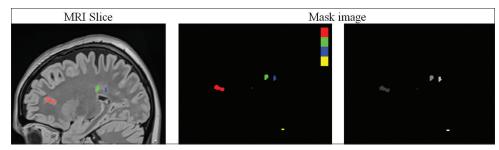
Magnetic resonance imaging slice of a patient containing several lesions in different places of the brain in addition to its corresponding mask slice, in color and gray scale formats, which show the segmented lesions. Lesions in different places of brain have been shown with different intensities or colors, where in the colored image, the red, green, blue, and yellow colors correspond to lesions in periventricular, white matter, juxtacortical, and infratentorial, respectively
